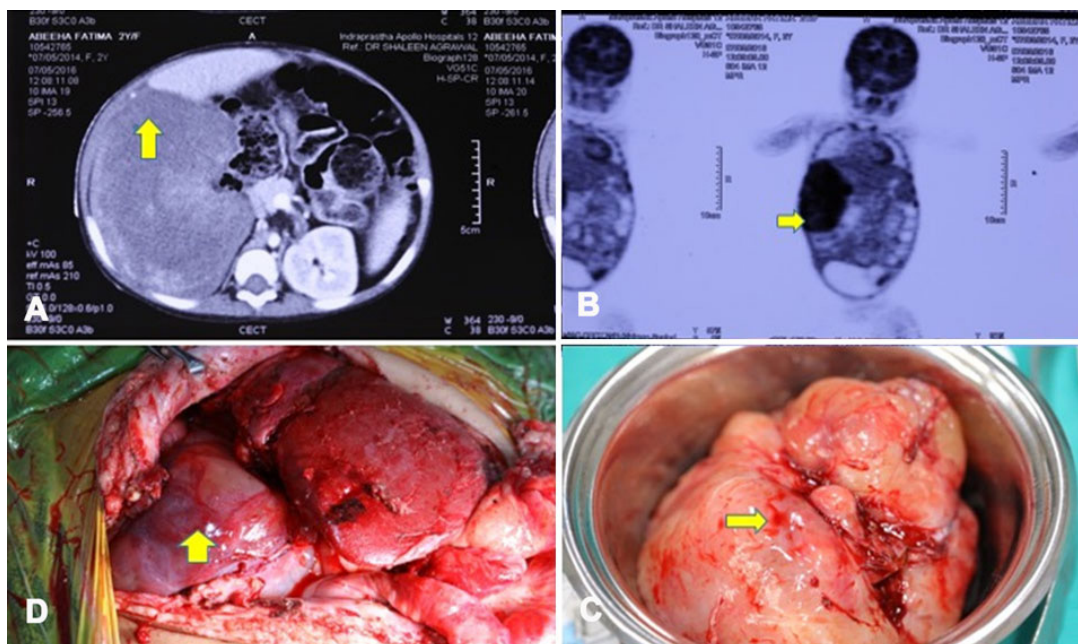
Clinical pictures of the case report. (A) Cross sectional image showing the tumor along the cut surface of the graft liver; (B) coronal section of the PET-CT image showing PET avid lesions; (C) intra-operative picture showing one tumor near the cut surface of graft liver; (D) intra-operative picture showing the tumor masses along with the transplanted liver. PET: positron emission tomography; CT: computed tomography
